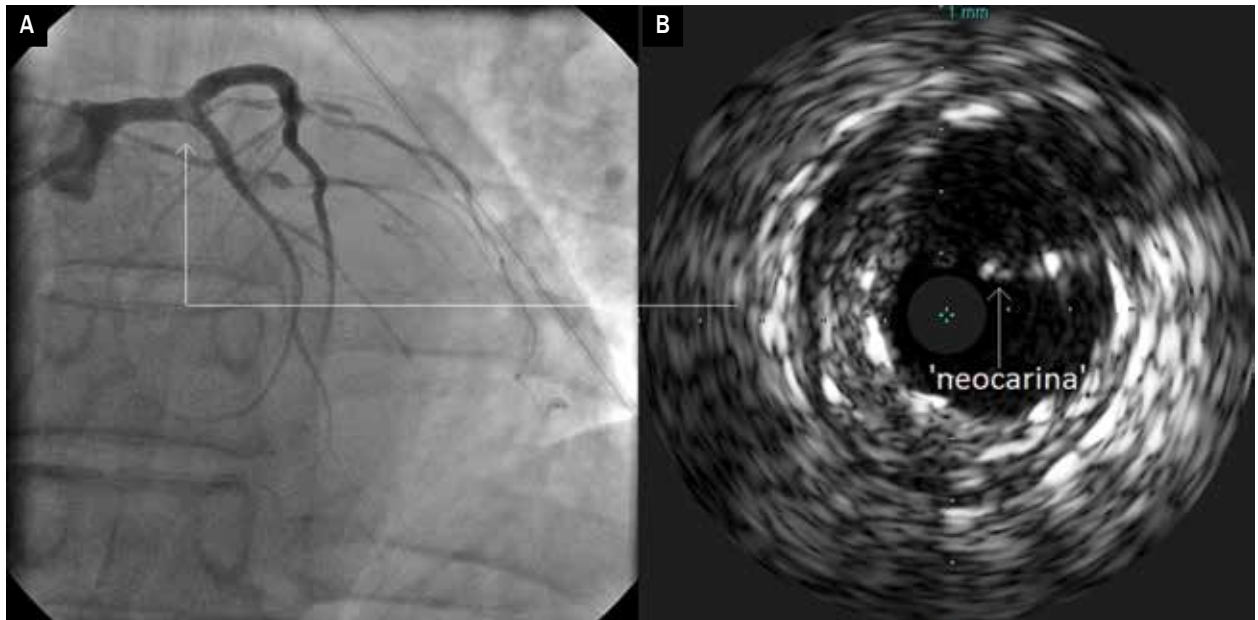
Coronary angiography showing some haziness in distal left main after stents implantation (A) and intravascular ultrasound showing incomplete stents apposition with “neocarina” in this area (B)
